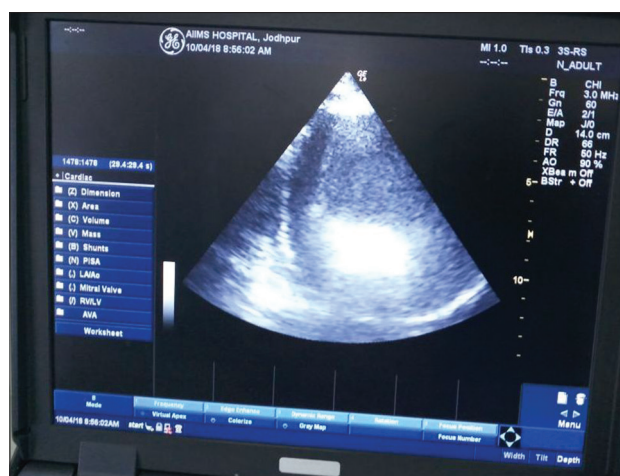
Two-dimensional echocardiography showing massive pericardial effusion
